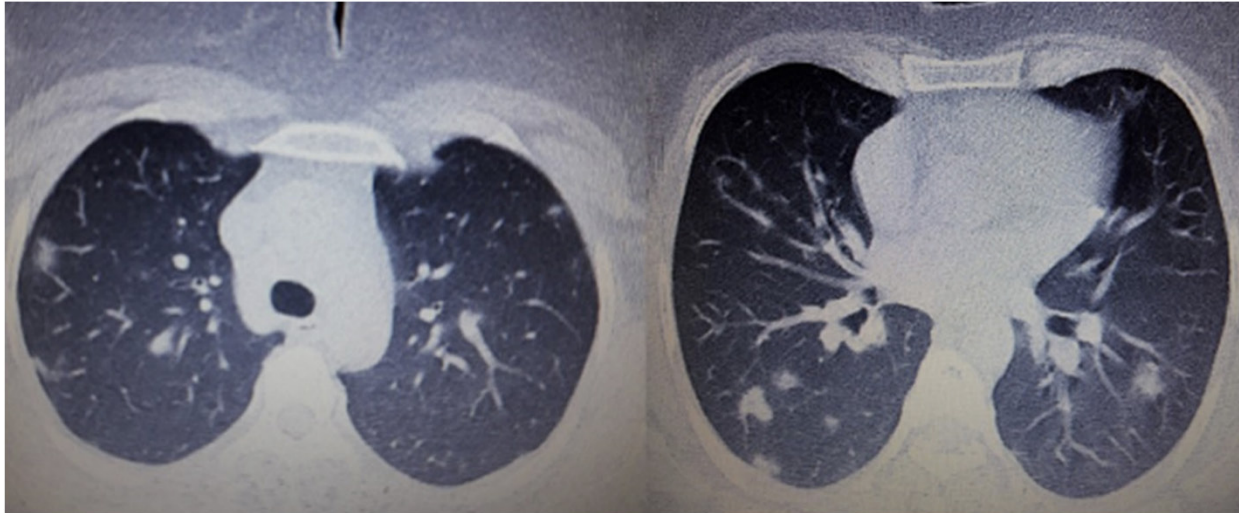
Thorax CT: bilateral, multifocal, peripheral, basal-predominant ground-glass opacities and consolidations.
